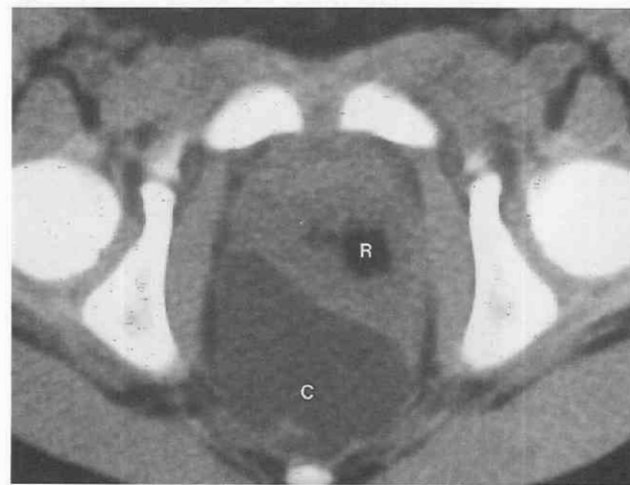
Rectal duplication cyst in a 4-year-old girl with chronic constipation. A nonenhanced CT scan shows a well-circumscribed ovoid cyst (C) of water attenuation in the presacral region displacing the rectum (R) anteriorly.
